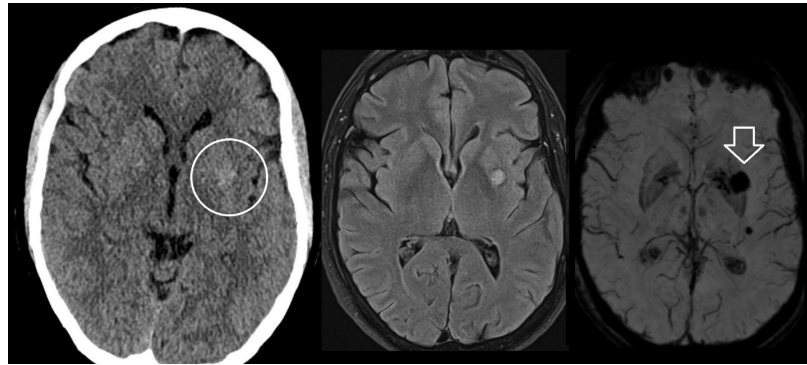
Cavernoma. A 68-y/o with HTN, developed minutes of immobility in the right hand and fingers when attempting to open the refrigerator door, associated with left-sided headache. A subtle hyperdensity is observed on head CT (white circle), corresponding with changes on the FLAIR (middle), and SWI (arrow).
